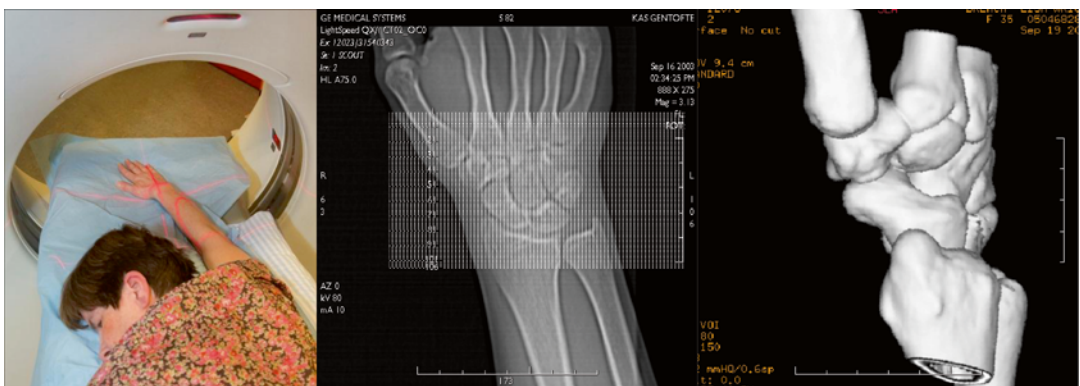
CT scan in 3 planes with reconstruction
